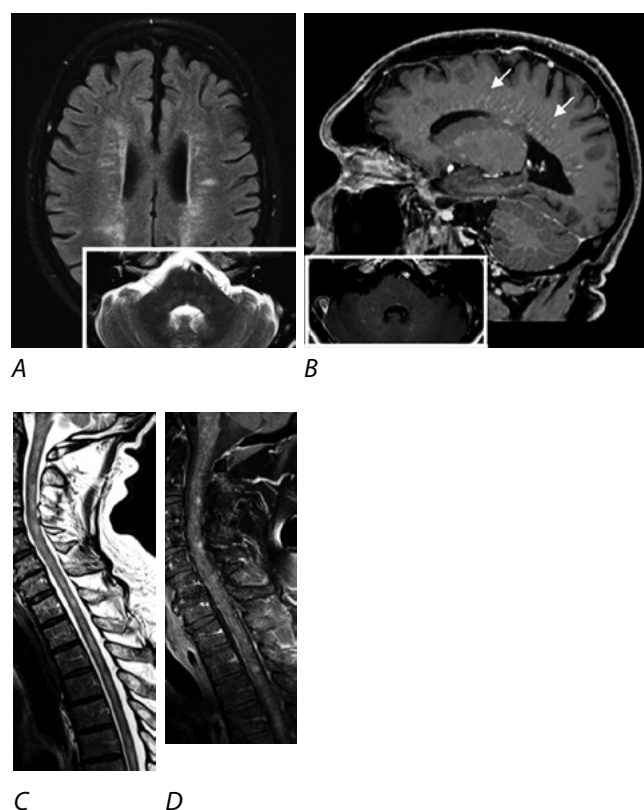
Patient M.'s brain and spinal MRI (October 2021).
